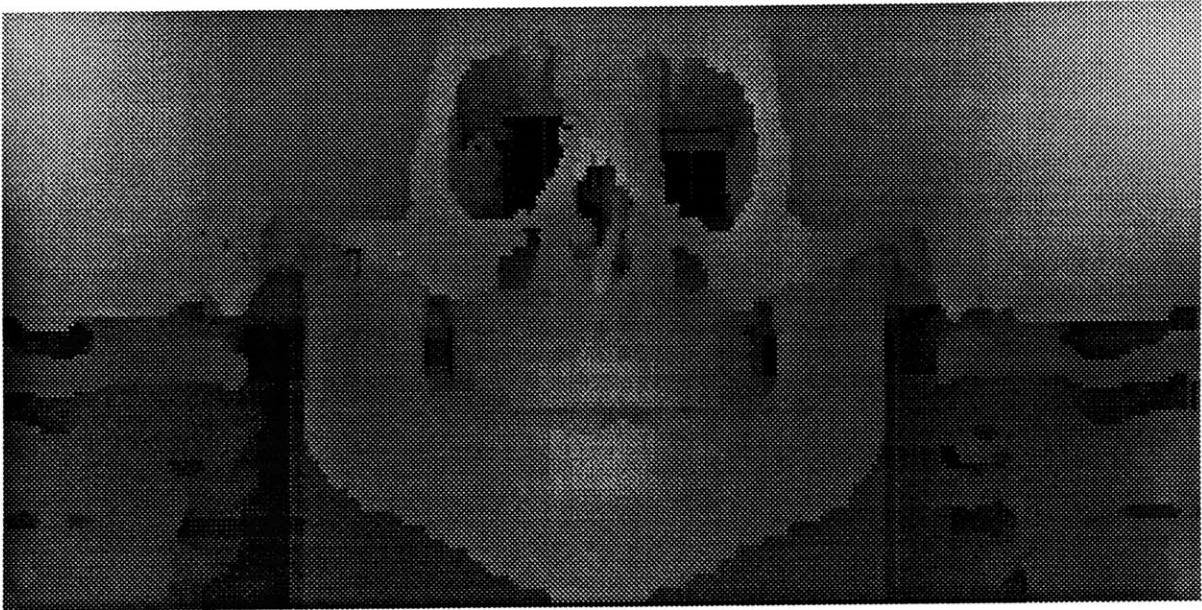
Bone surface range map derived from CT scan.
